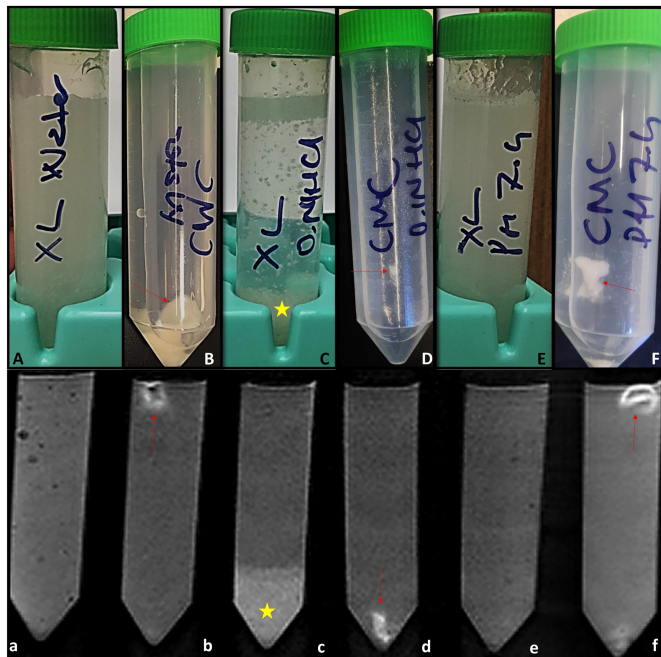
MR experiments of the oral contrast agents (lactulose and polyethylene glycol solutions are not shown here). Contrast agent-containing tubes were placed in a 32-channel head coil [upper line, LBXG in water (A-a), carboxymethyl cellulose in water (B-b), LBXG in an acidic environment (C-c), carboxymethyl cellulose in an acidic environment (D-d), LBXG in an alkaline environment (E-e), and CMC in an alkaline environment (F-f)]. There are many clumps in CMC solutions (arrows) on T1W MR images of the tubes (lower line). Also, a prominent aggregation was observed within the tube of the enteric-coated LBXG granules in the acidic buffer (asterisks).
